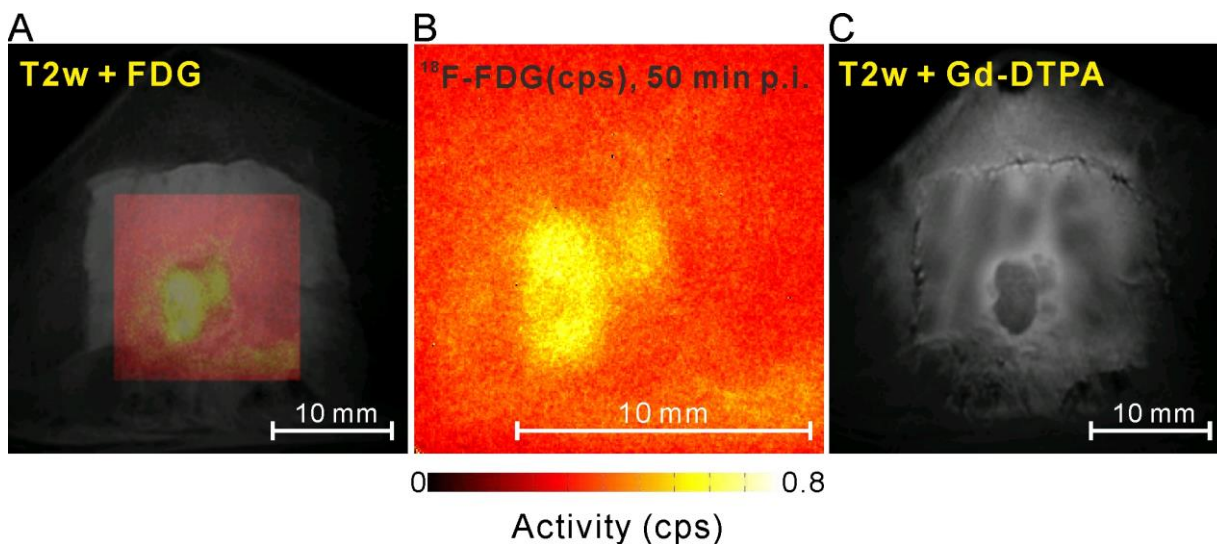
Positron imaging of the window chamber: (A) a merged image of the T2 weighted MRI image and ^{18}F -FDG uptake map of the positron image; (B) an ^{18}F -FDG map imaged 50 minutes after the ^{18}F -FDG injection, and the color bar beneath indicates color range versus radioactivity in counts per second (cps); (C) a T2 weighted MRI image after the contrast agent Gd-DTPA injection.
